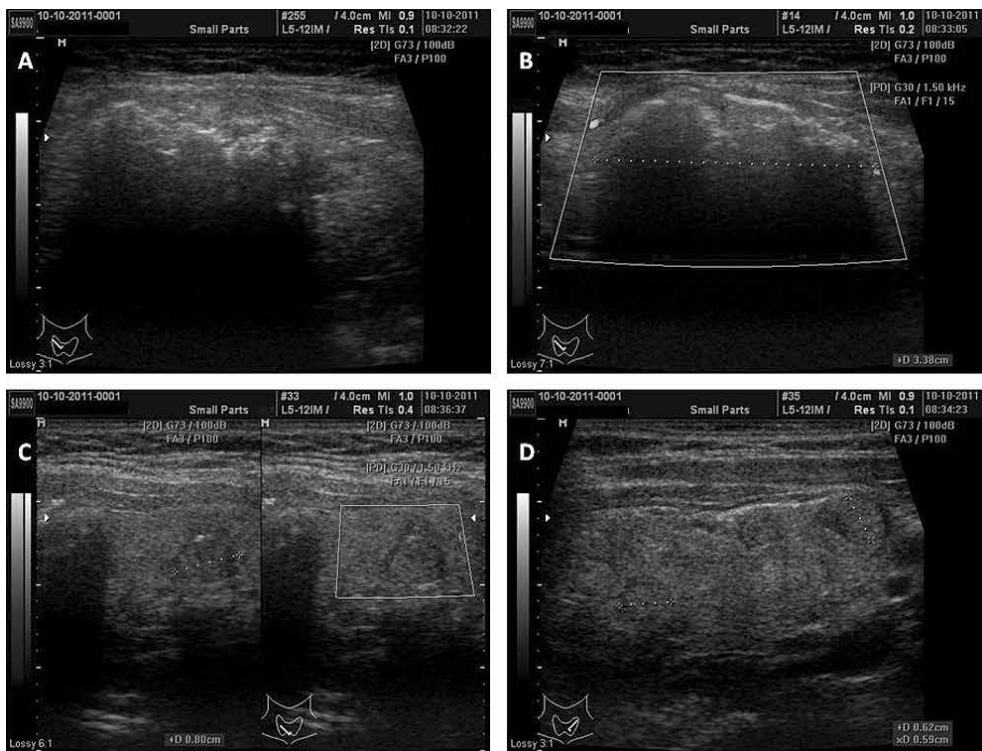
US scan of thyroid: the dominant nodule in the right lobe with calcified rim and type I blood-flow on colour-Doppler imaging (A, B), small isoechoic nodules with type I blood flow on colour-Doppler imaging in the rest of thyroid gland (C, D)
